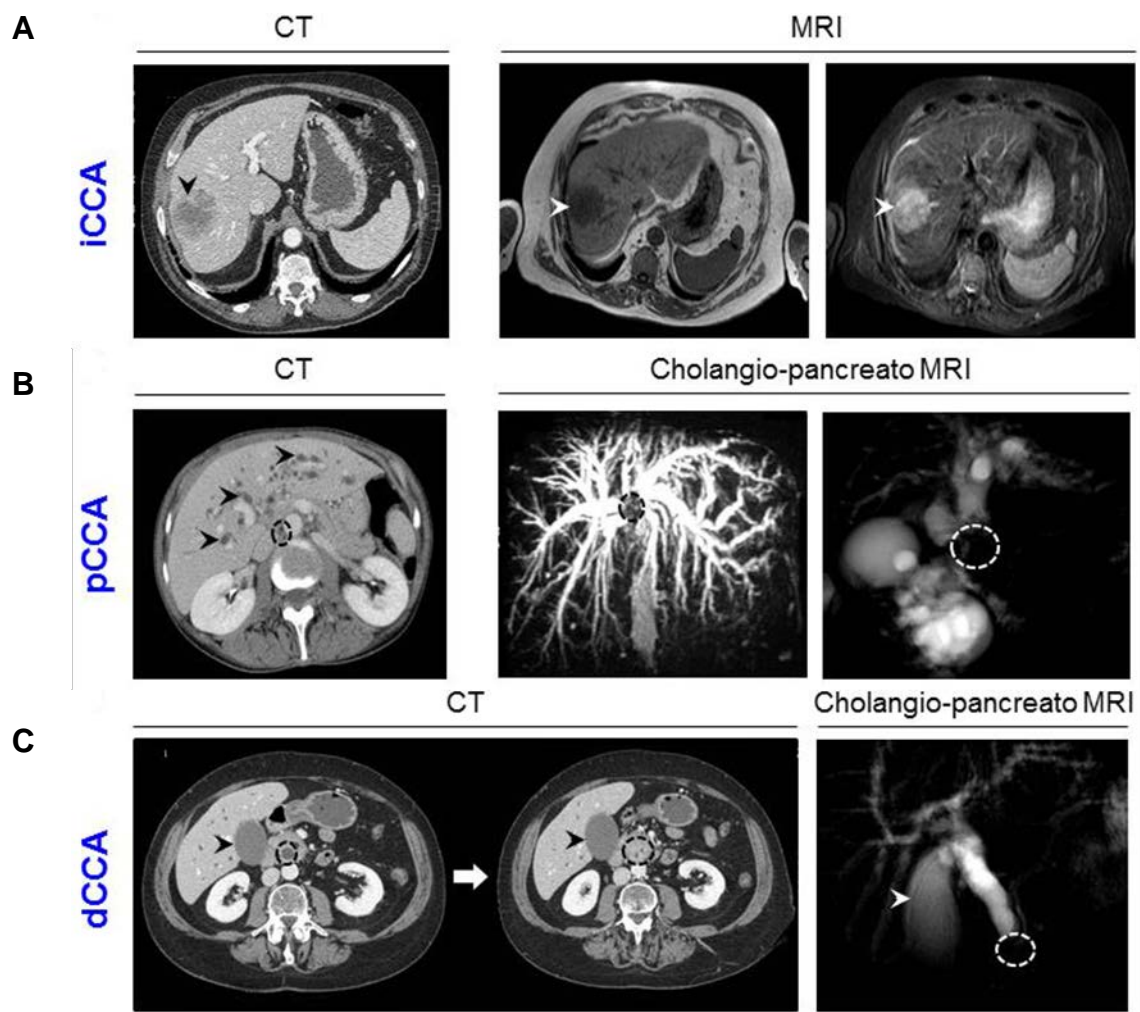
Diagnostic imaging methods for CCA. (A) Images of intrahepatic CCA (arrow) by computerized tomography (CT) and magnetic resonance imaging (MRI). (B) Images of perihilar CCA (circle) by CT [dilatated bile ducts within the liver are shown (arrows)] and by cholangio-pancreato MRI. (C) Images of distal CCA (circle) with extended gallbladder (arrow) by CT (two sequential images) and cholangio-pancreato MRI [41].
